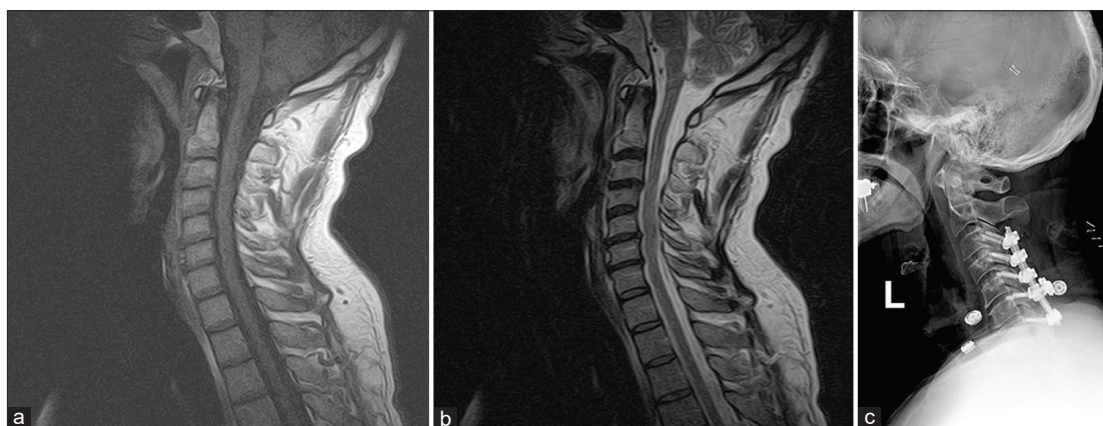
Perioperative imaging of the cervical spine fusion performed in 2008. (a) Preoperative T1-weighted magnetic resonance imaging (MRI) of the cervical spine. (b) Preoperative T2-weighted MRI of the cervical spine. No significant foci are noted, but canal stenosis is visible from C3-C6. (c) Postoperative X-ray demonstrated instrumented fusion from C3-C7. “L” denotes that the image taken from the left side of the patient’s body.
